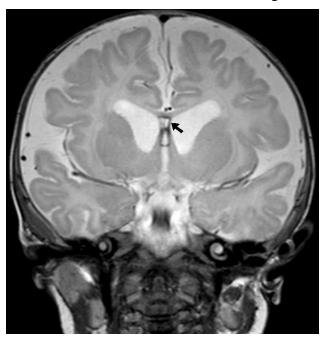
MRI obtained at 3.5 months of life showing the disappearance of the clot inside the cavum septum pellucidum and the decreased dilatation. Notice the persistence of the haemosiderin deposits on the septum pellucidum (arrow) and on the ventricular walls.
